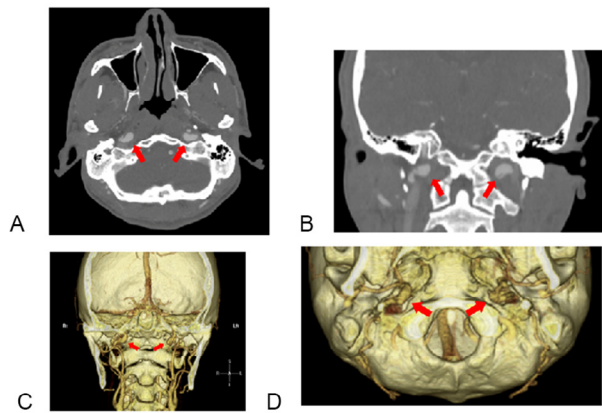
Computed tomography angiography (A: axial image; B: coronal image) and 3-dimensional computed tomography angiography (C and D). The arrows indicate bilateral internal carotid artery aneurysms at the subpetrosal portion. These aneurysms are located just under the jugular foramen.
